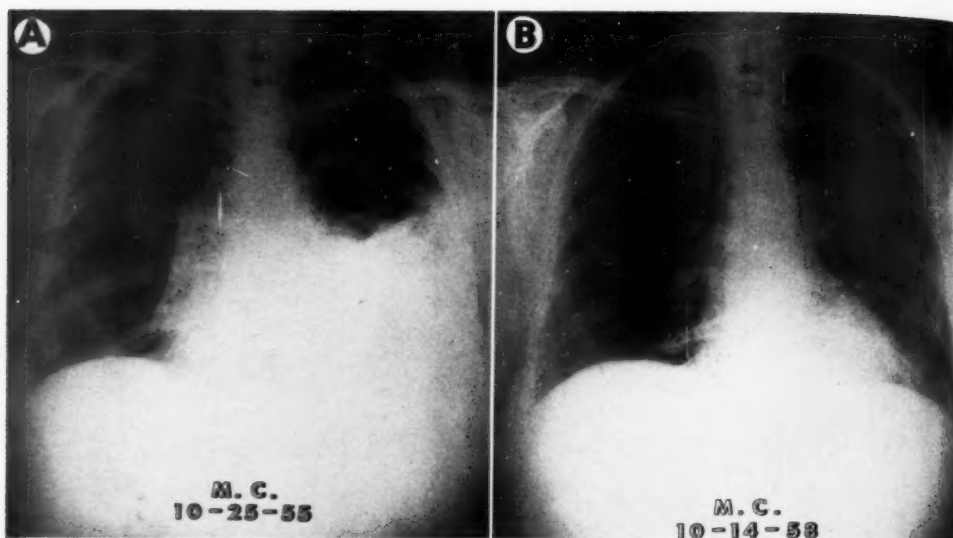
Case II. A. Chest roentgenogram made on Oct. 25, 1955, showing left pleural effusion in patient with lymphosarcoma.
